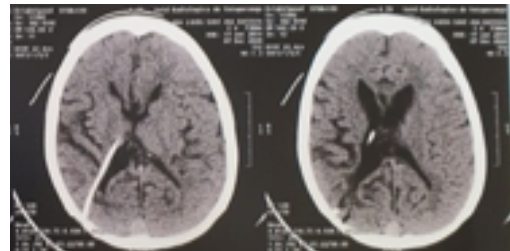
Post operative Computed tomography in sagittal section demonstrating improvement in hydrocephalus
